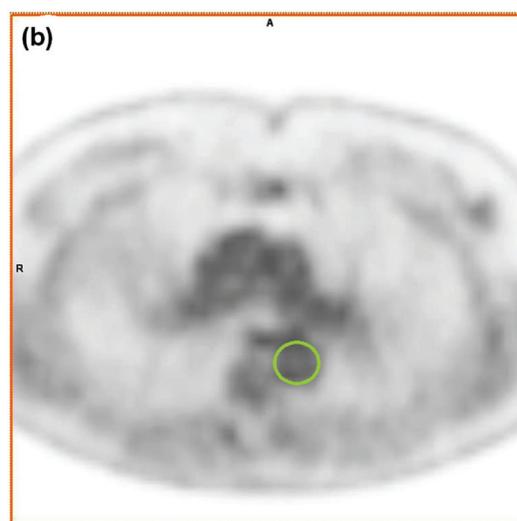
Typical regions of interest placement for the aorta guided by computed tomography
